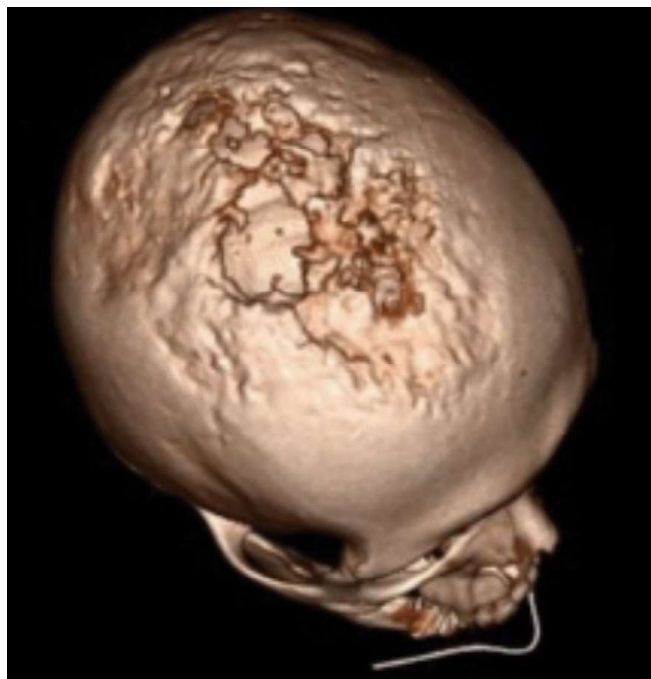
3D CT scan showing the extent of the PDS destruction of the skull.
